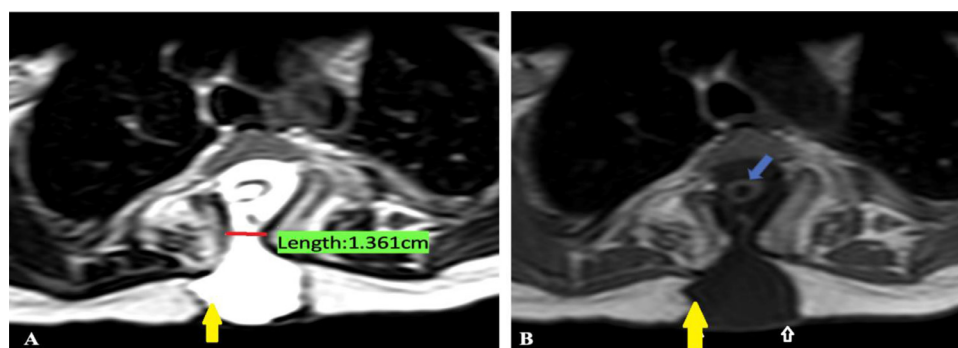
Axial MRI images (Figure 1A-T2 weighted and Figure 1B-T1 weighted) demonstrate a bony defect in the neural arch of D5 vertebra measuring approximately 13.6 mm (red horizontal line in Figure 1A). A cystic protrusion showing high signal intensity on T2 weighted image (yellow arrow in Figure 1A) and low signal intensity on T1 weighted image (yellow arrow in Figure 1B) is also noted. The overlying skin is intact (white arrow in Figure 1B). In addition, there is dilatation of the central canal of the spinal cord (blue arrow in Figure 1B).
